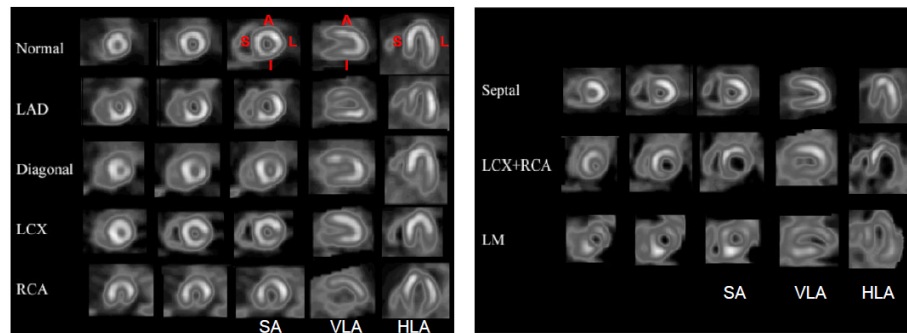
Pattern of ischemia in various coronary artery territories in SPECT images. Reproduced from Fuster et al.^[39]
